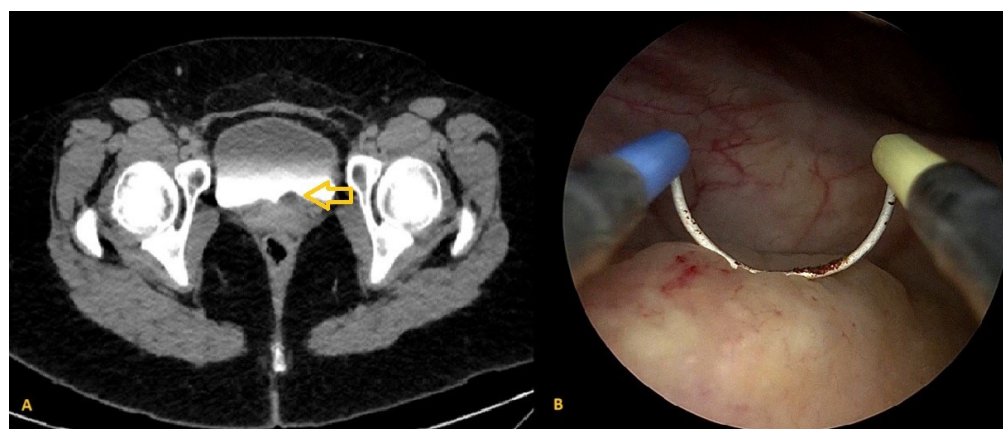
A nodular lesion in the lateral side of the left ureter orifice of the bladder (A. CT transverse section, B. Endoscopic images of nodular lesions in the bladder)
